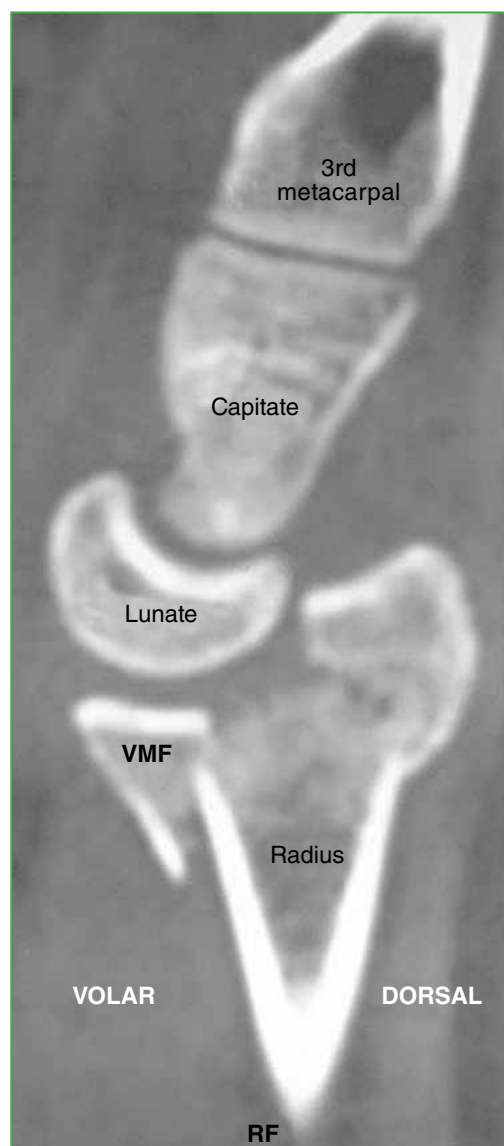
Wrist CT sagittal section. Image reveals distal radius intra-articular fracture and volar marginal fragment distal to the watershed line. VMF = volar marginal fragment.
